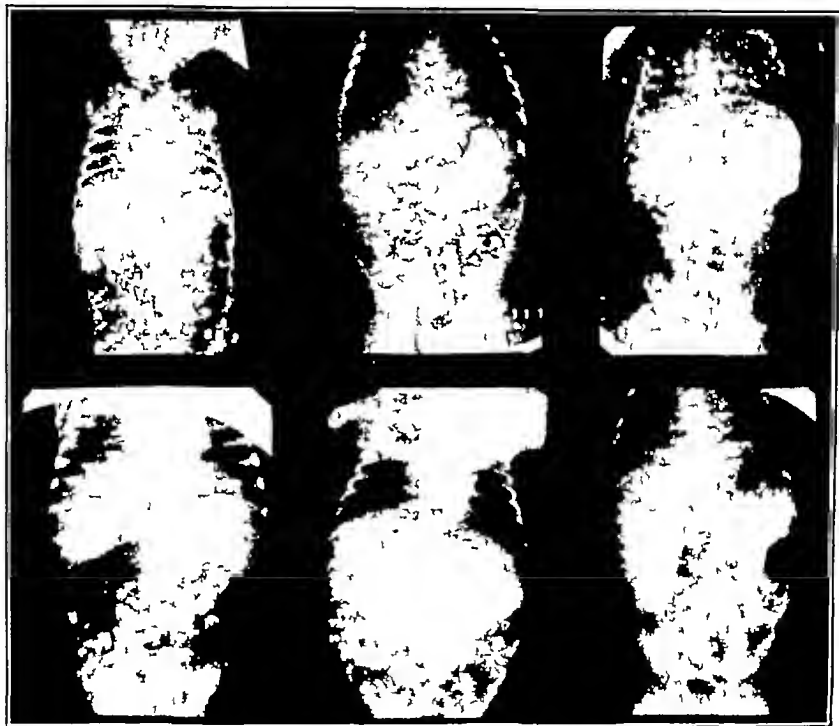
Roentgenograms of stomachs of six infants from 3 weeks to 4 months old showing different sizes and shapes.
